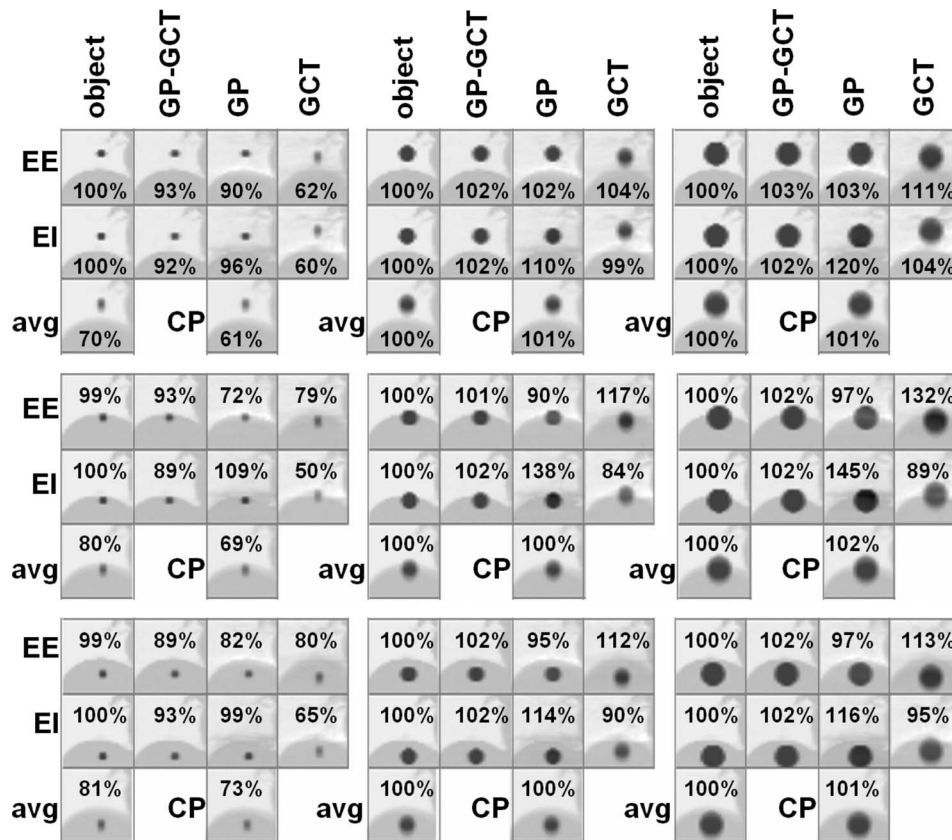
Coronal sections through PET series associated with mobile 10, 20, and 30 mm tumors in patient 2, at end expiration (EE) and end inspiration (EI), the average (avg), and conventional PET (CP). The top three rows of the figure show tumors in the lower right lung. Middle: at the dome of the liver. Bottom: in the upper lobe of the liver. The left four rows: 10 mm tumors. Middle: 20 mm. Right: 30 mm. Percentages printed in the figure are SUV recovery values.
